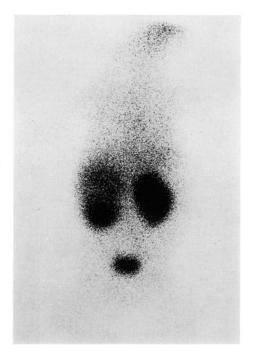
Renal scintigram with <sup>99m</sup>Tc-DMSA reveals abnormal uptake on the right kindey which is larger than the normally appearing counterpart.
